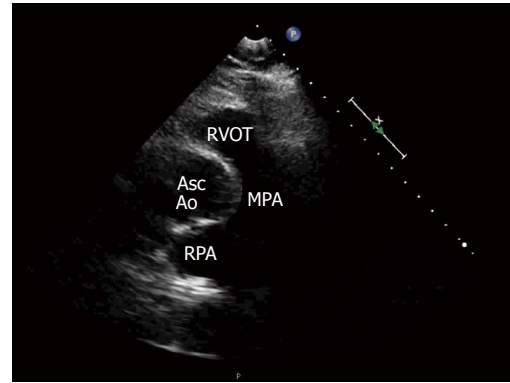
Parasternal ascending aorta short axis view, sonogram. RVOT: Right ventricular outflow tract; AscAo: Ascending aorta; MPA: Main pulmonary artery; RPA: Right pulmonary artery.
